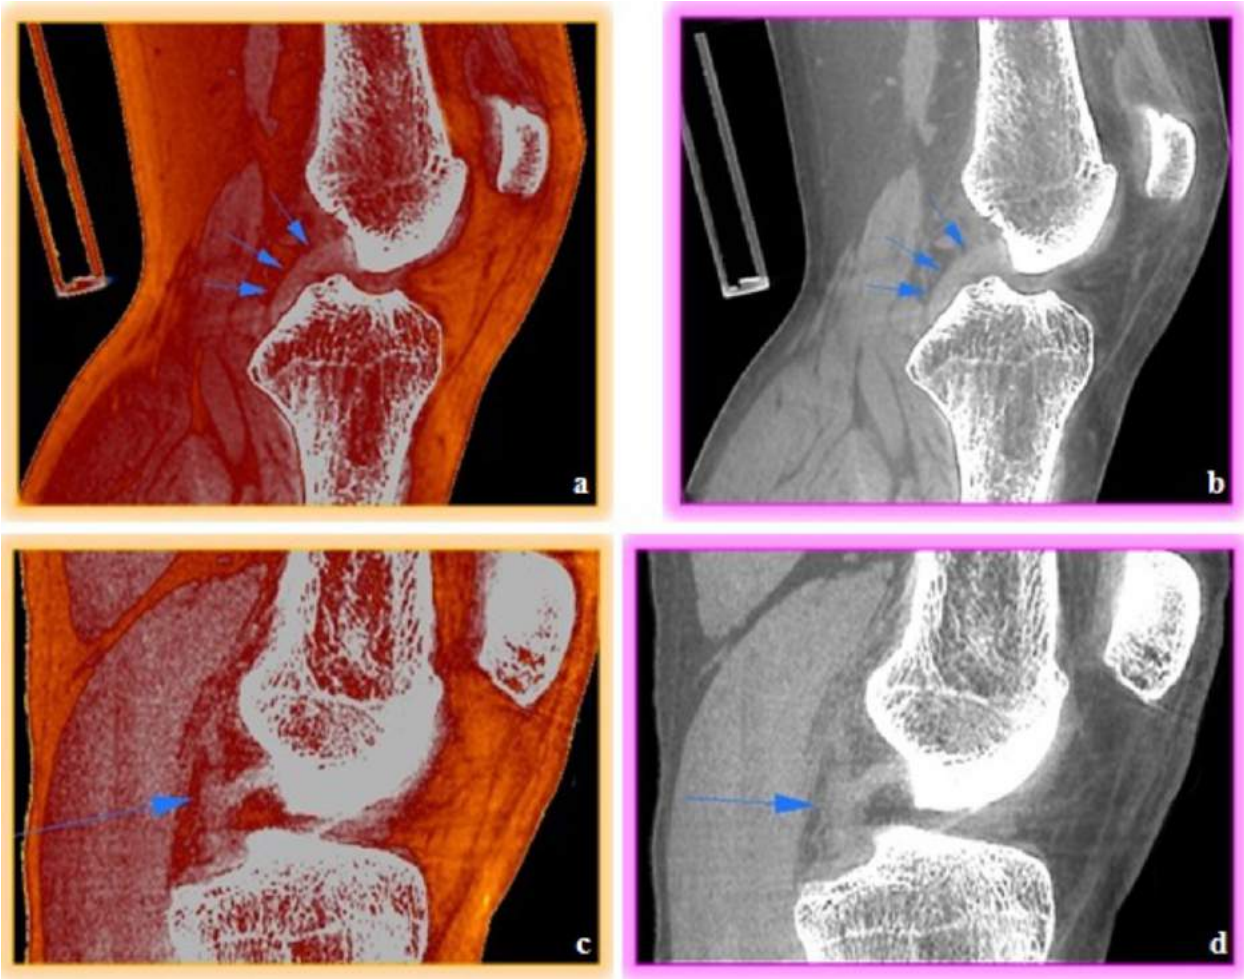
the CBCT-images of the left knee joint with the accurate differentiation of the cystic and osteosclerosis lesions even under 1 mm
